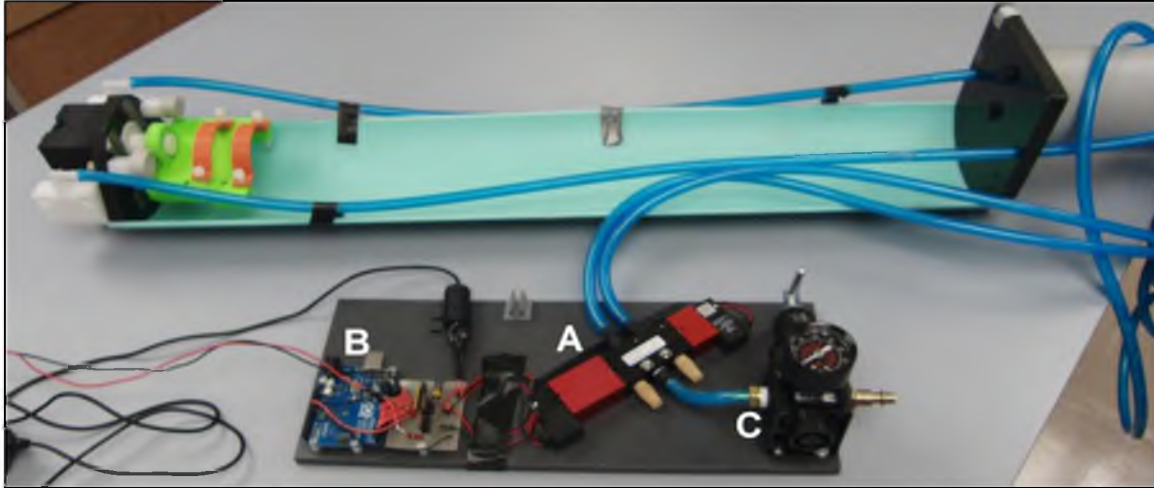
The completed custom MRI bed with pneumatic control panel. The pneumatic actuation was controlled with a dual-action pneumatic solenoid (A), triggered by an Arduino Uno R3 micro-controller (B). Pressure was regulated with a 0-120psi range pressure regulator (C).
